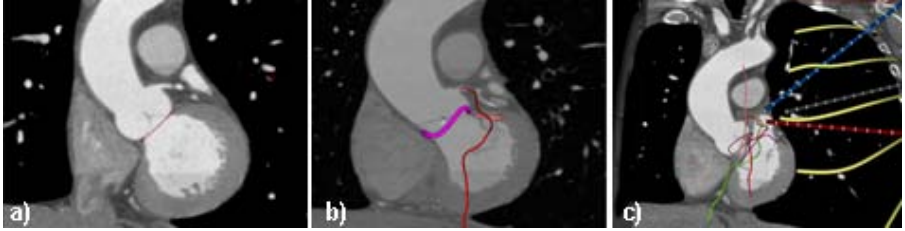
Pre-operative planning stage showing patient's cardiac CT scan (a), the coronary vessel displayed relative to the valve annuli (b) and the port placement to ensure proper reach of the target vessel with the robotic instruments (c) *Note: the yellow lines represent intercostal spaces.*
